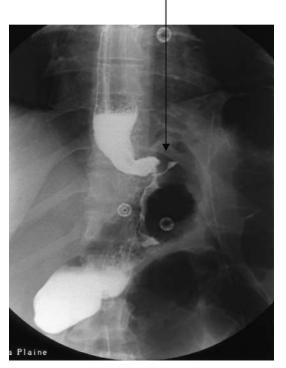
Leakage along the stapler line, diagnosed on x-ray control.
